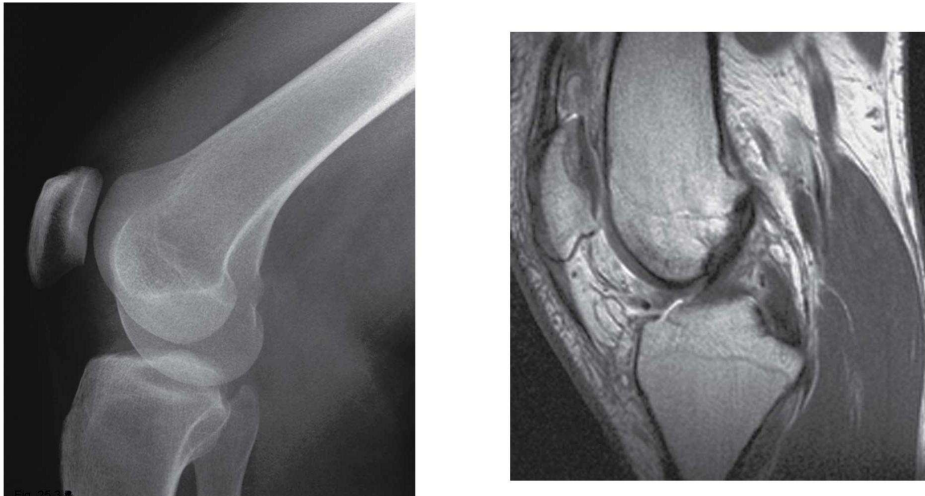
Lateral radiograph showing the bones in the joint, Sagittal slice of an MRI of the knee, MRI enables to visualize other tissues than bone (figures reproduced from 'Atlas of anatomy', Gilroy Anne M et.al. fig. 25.3.B and fig.25.18.)
